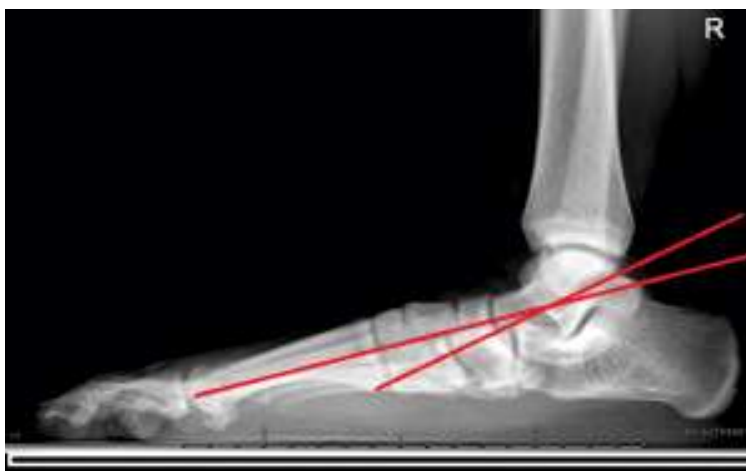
Pes Planus on lateral standing x-ray. Meary's angle is the angle between a line drawn from the centers of longitudinal axes of the talus and the first metatarsal. In the normal foot, Meary's angle is roughly zero: the two lines are parallel.
